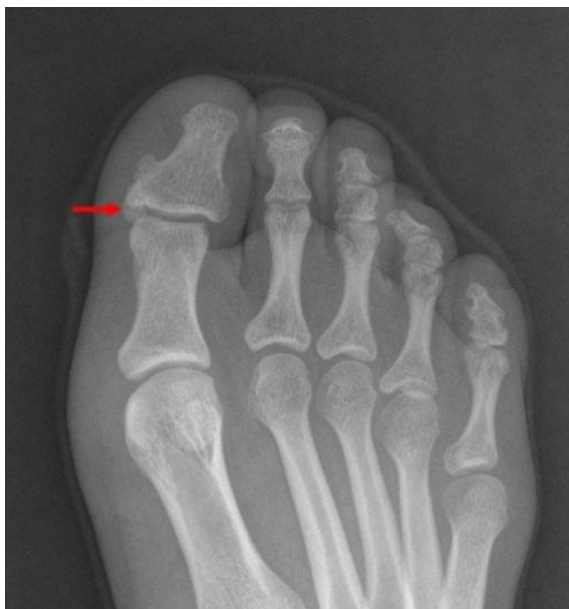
AP radiographs showing hallucal sesamoid bone in a 32-year-old female (red arrow)
